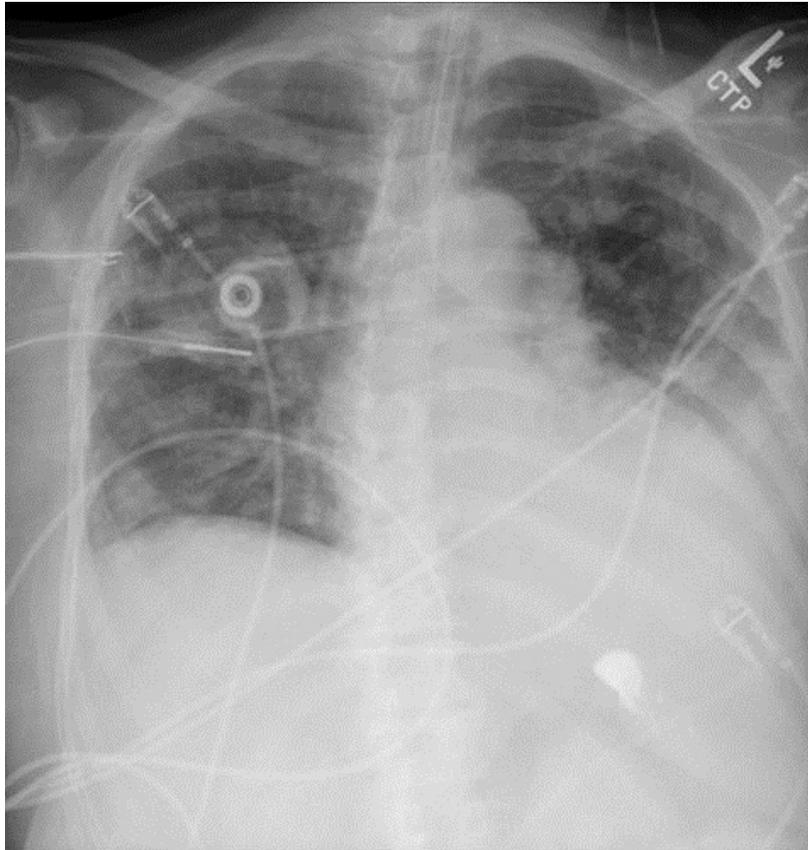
Repeat frontal chest radiography.
